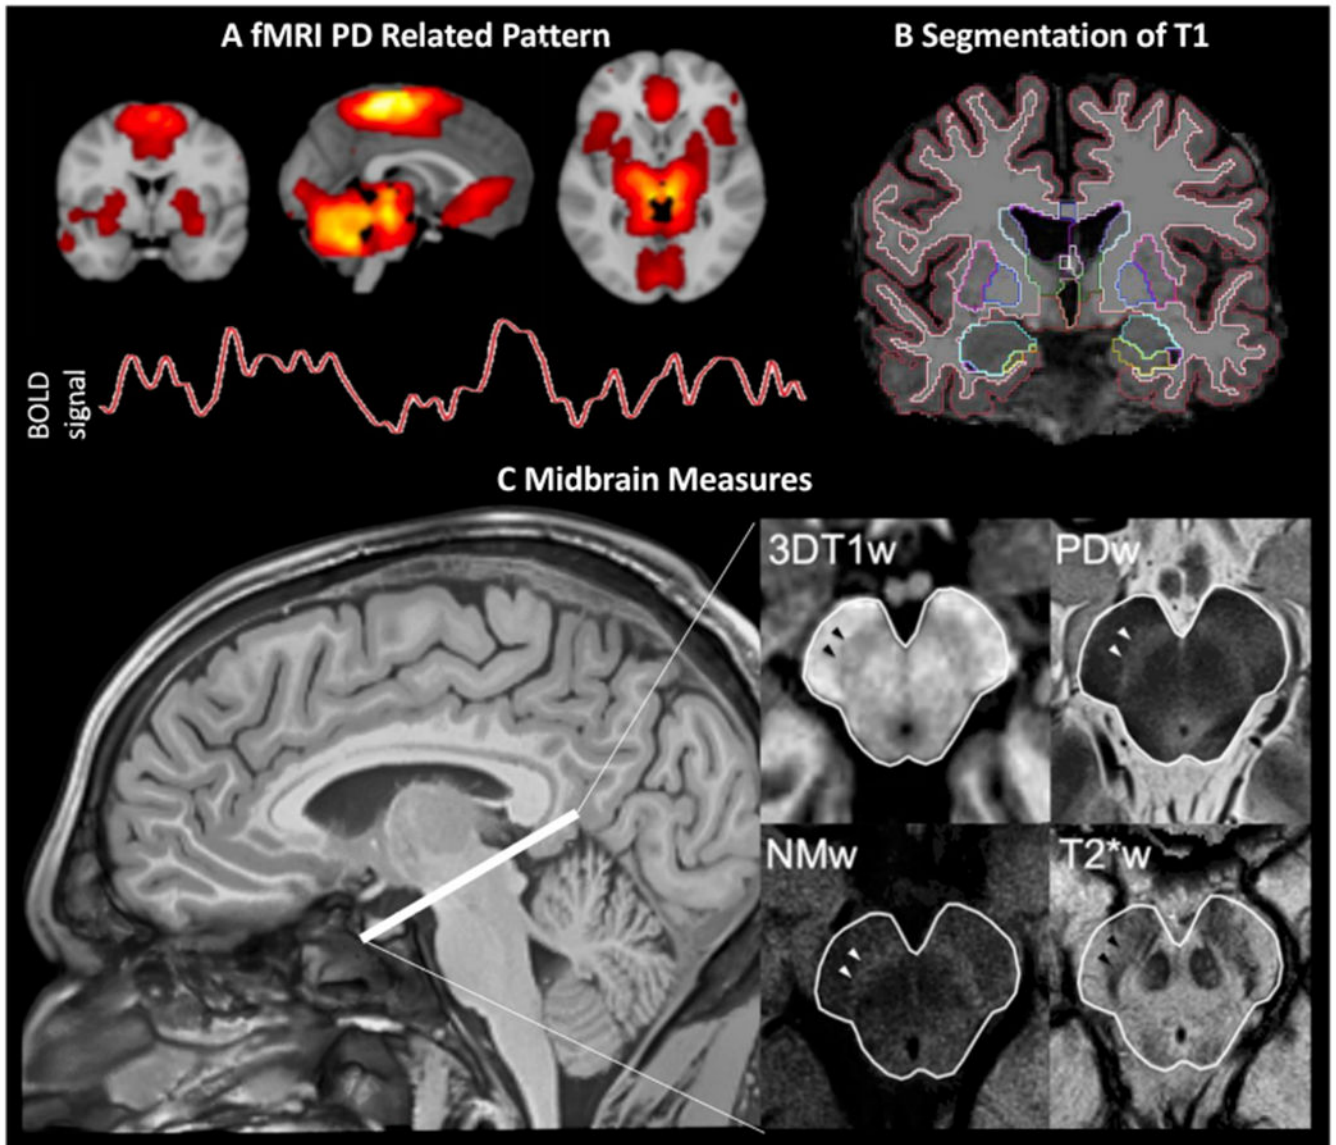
Common MRI methods used to study Parkinson's disease.
